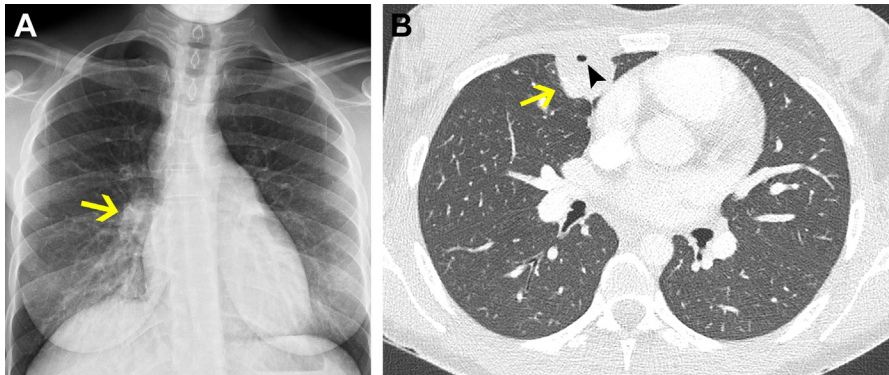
Cryptococcosis. (A) Posteroanterior chest radiograph shows a nodular opacity adjacent to the right heart border (arrow). (B) Nonenhanced CT shows a cavitated mass in the middle lobe (arrow).
